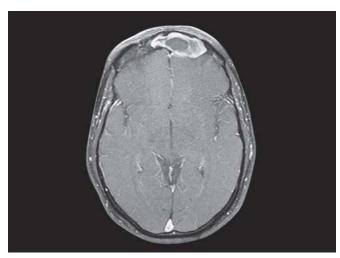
Axial cut of contrast MRI showing mucosal enhancement in fontal sinus
